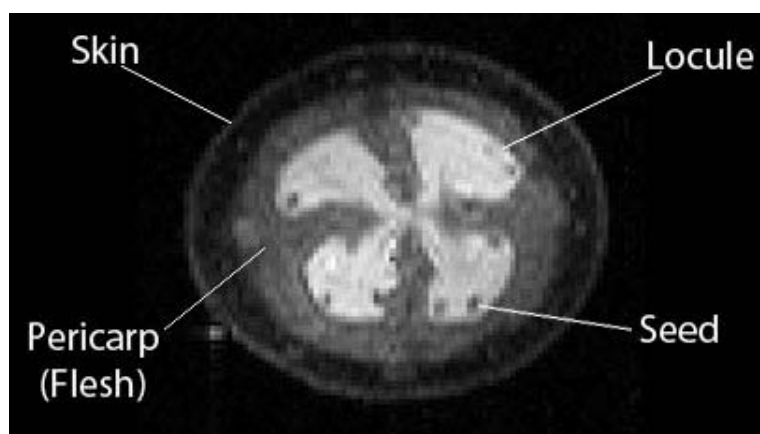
Two-dimensional MR image of feijoa fruit, the brighter the image the stronger the signal.
